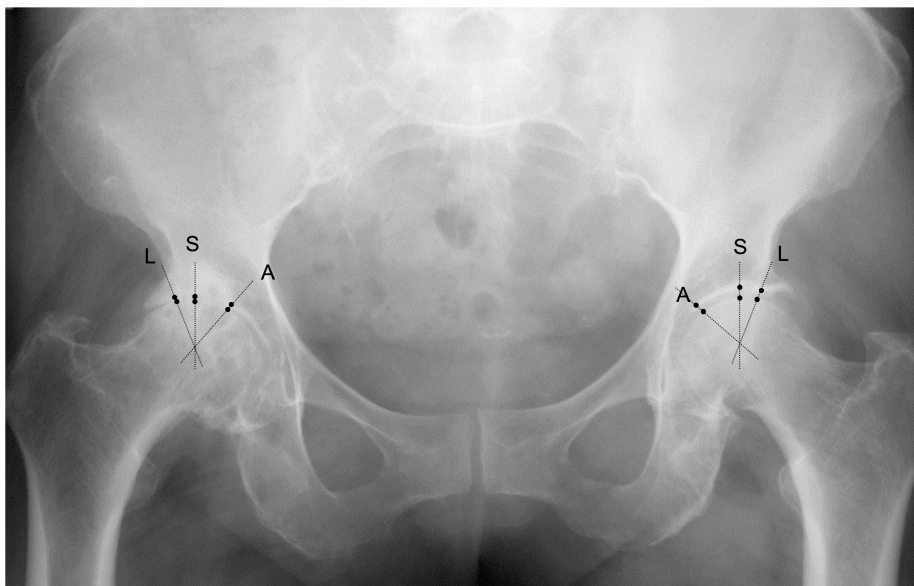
Supine anteroposterior pelvic X-ray showing articular degenerative signals affecting both hips with different intensities; in both hip joints are depicted the locations for JSW measurement: Lateral (L), superior (S), and axial (A).
